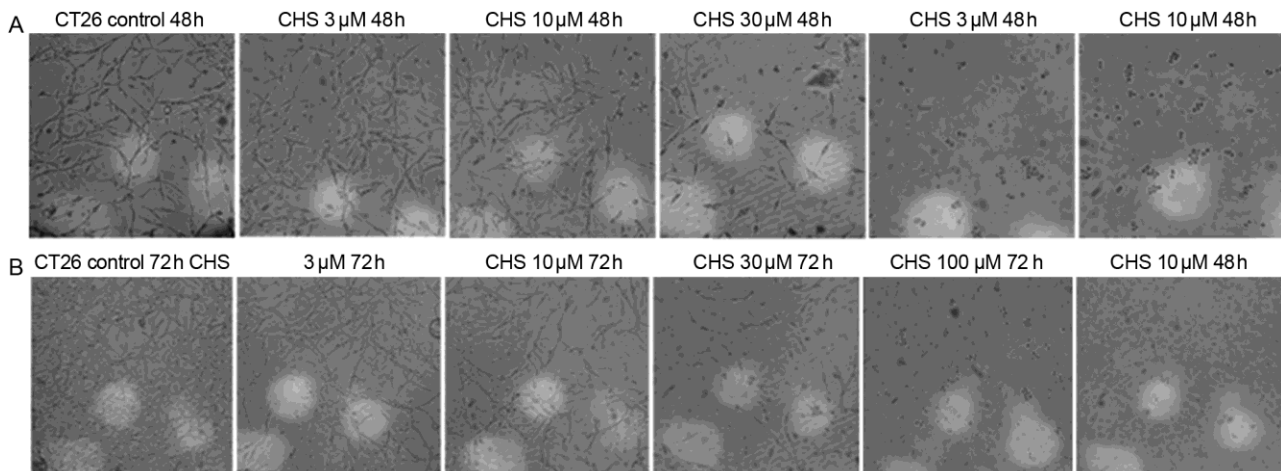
Morphological changes of the CT-26 cells following treatment with different doses of chalcone 5 after (A) 48; and (B) 72 h
